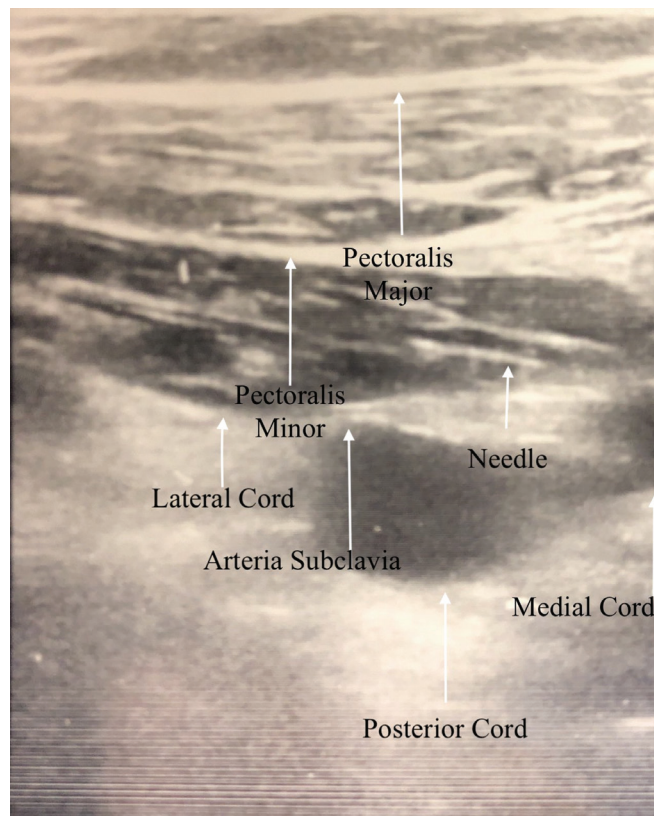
Section view of ultrasound-guided infraclavicular block
